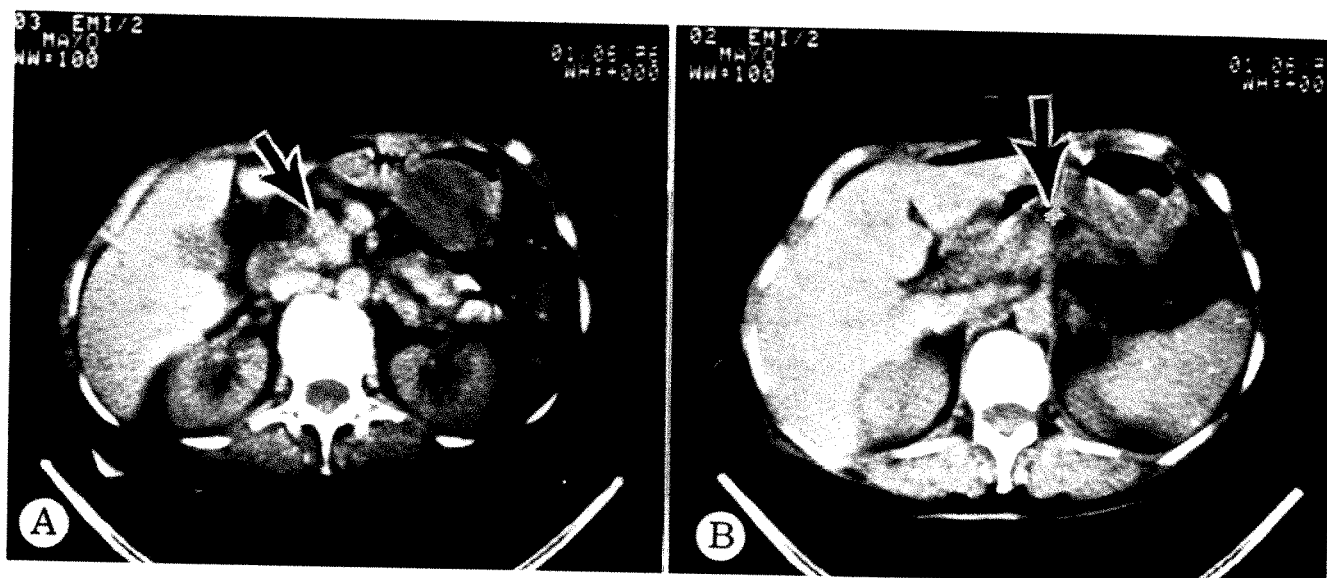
CT scans of 69-year-old woman with weight loss and abdominal pain. B-scan ultrasound showed possible lesion in head of pancreas. A, Irregular lobulated mass (arrow) posterior to stomach and medial to second portion of duodenum. B, Stomach displaced anteriorly by large ill-defined mass in body of pancreas containing lucent area suggesting pseudocyst (arrow). At operation, lobulated carcinoma in head of pancreas found associated with pseudocyst in midportion of body of pancreas.
